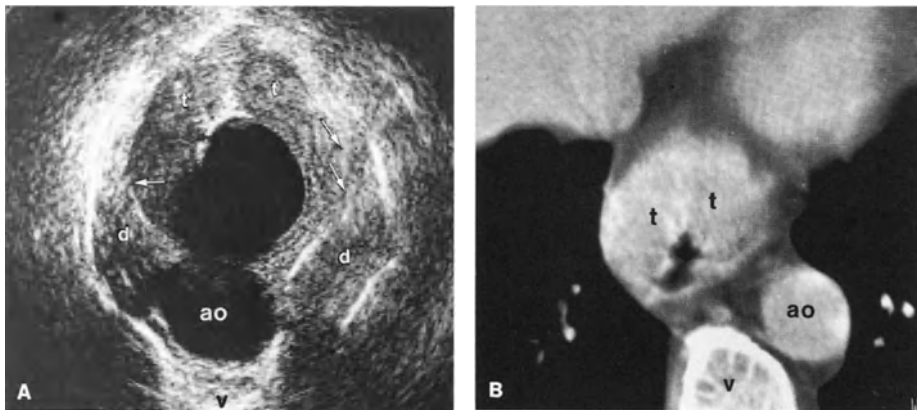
A Endoscopic sonogram showing an extensive hypoechoic transmural tumor mass (*t*), with penetration into the surrounding tissues. Note the unclear demarcation into the surrounding tissues. Note the unclear demarcation of the tumor mass (*arrows*) and the diaphragm (*d*) bordering the aorta (*ao*). B Corresponding computerized tomography scan section, showing thickening of the esophageal wall (*t*). The penetration into the diaphragm is not visualized
